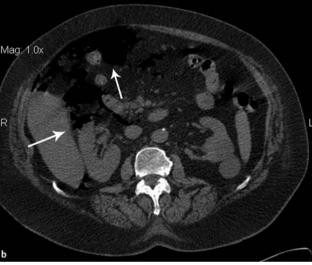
Computed tomography (CT) scan depicting free air in the peritoneal cavity and retroperitoneum (white arrows): a patient 2.
